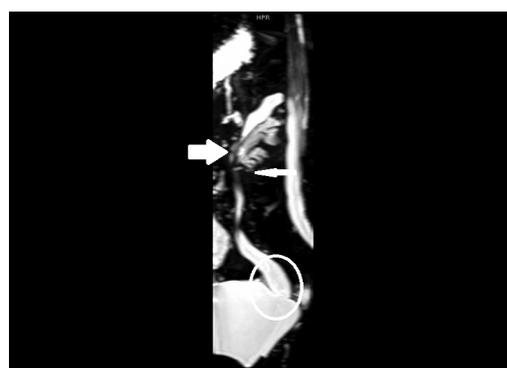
Magnetic resonance imaging demonstrates the presence of a left duplicated collecting system (upper pole, bold arrow; lower pole, narrowed arrow; white circle, presumptive insertion of the duplicated system into the bladder without evidence of the ectopic prolapsed ureterocele).
